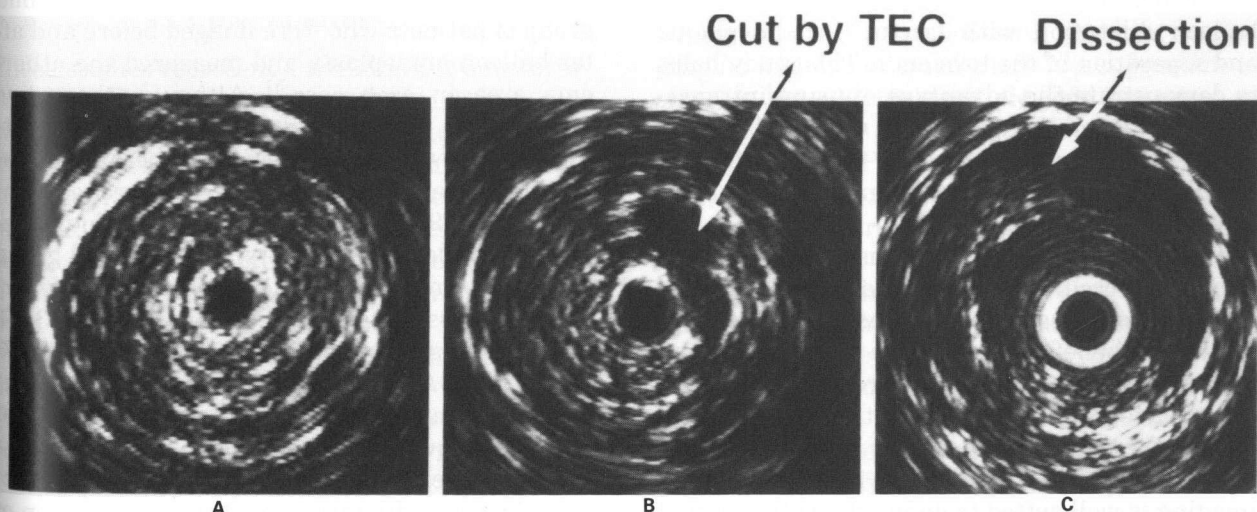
Peripheral TEC atherectomy: These three intravascular ultrasonic images were taken at the same section of an occluded superficial femoral artery that was reopened with a standard guidewire and catheter. (A) Following recanalization, a huge amount of fibrous plaque surrounds the catheter. At this place in the artery, the pathway of canalization was in the central portion of the plaque. (B) Following an atherectomy that was performed with a 2.7-mm TEC device. There has been some enlargement of the lumen and some excision of plaque shaped like a trough (arrow) from 11 o'clock to 1 o'clock. (C) Following balloon dilatation with a 7.0-mm balloon, there is fracture of the plaque through to the media with separation of the torn ends and dissection of the ends of the plaque away from the media (arrow). This produces a large increase in luminal cross-sectional area in this segment.
